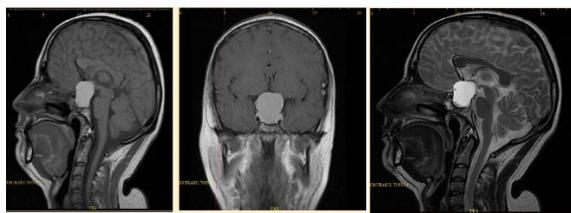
Brain MRI results
